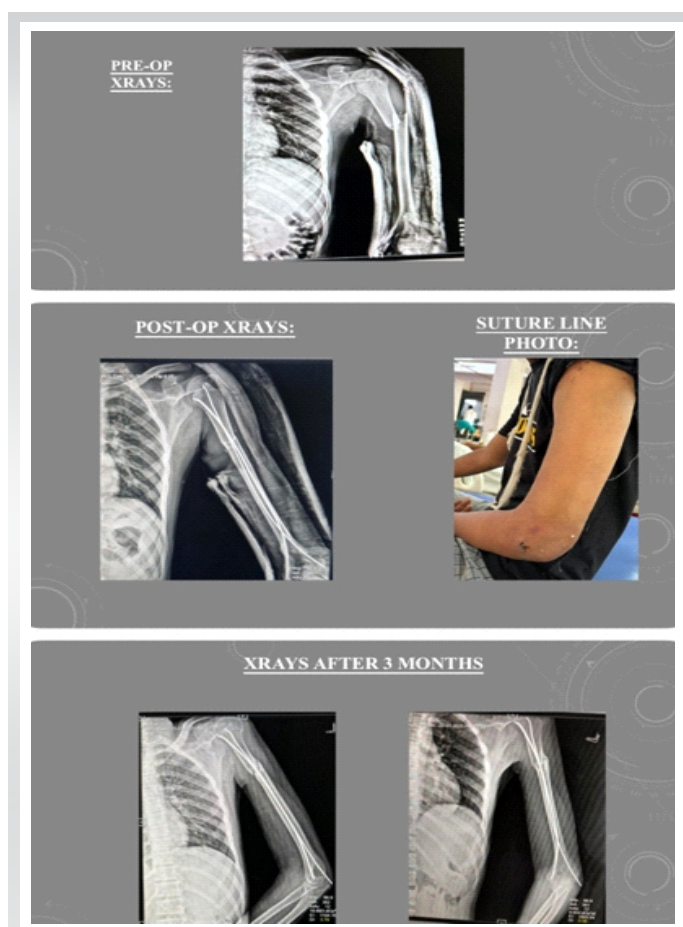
(a and b) Pre-operative and post-operative radiographs – Case 1.
